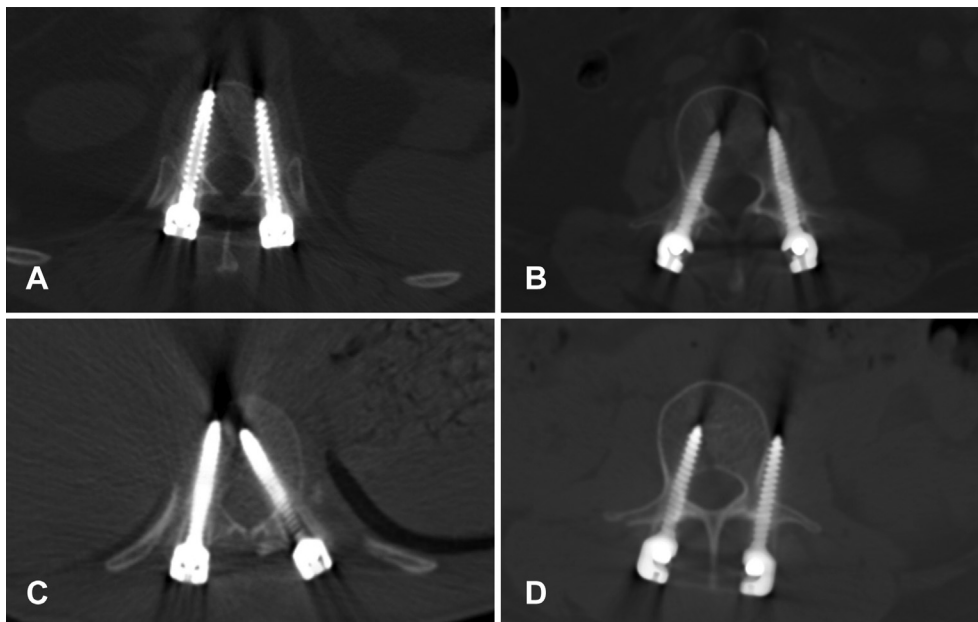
Grading used for pedicle perforation on axial CT scan and the representative images: (A) both pedicle screws completely within the pedicle (Grade 0); (B) Grade 1 (<2 mm) perforation of the medial wall of the right pedicle and Grade 2 (2–4 mm) perforation of the lateral wall of the left pedicle; (C) Grade 2 (2–4 mm) perforation of the medial wall of the left pedicle and Grade 0 perforation of the right pedicle; (D) Grade 3 (>4 mm) perforation of the lateral wall of the left pedicle and Grade 1 (<2 mm) perforation of the medial wall of the right pedicle. CT, computed tomography.
